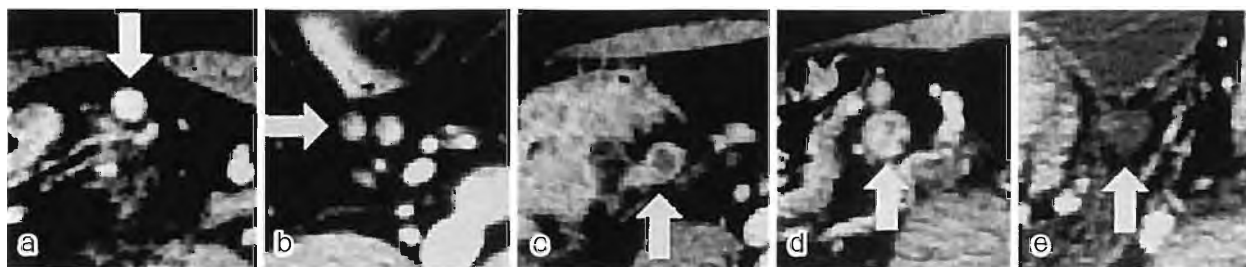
Images of lymph nodes in thin slices 40 s after injection of contrast medium a, homogeneously enhanced; b, partially enhanced; c, marginal only; d, spotted; e, no enhancement. In contrast CT, metastasis may be negative when lymph nodes are homogeneously (a) or partially (b) enhanced in thin slices 40 s after injection of contrast medium; and metastasis may be positive when only the marginal region is enhanced (c), there is a spotted pattern of enhancement (d), or there is no enhancement (e). (This figure was reprinted from reference 39, Fig. 6 with permission.)
